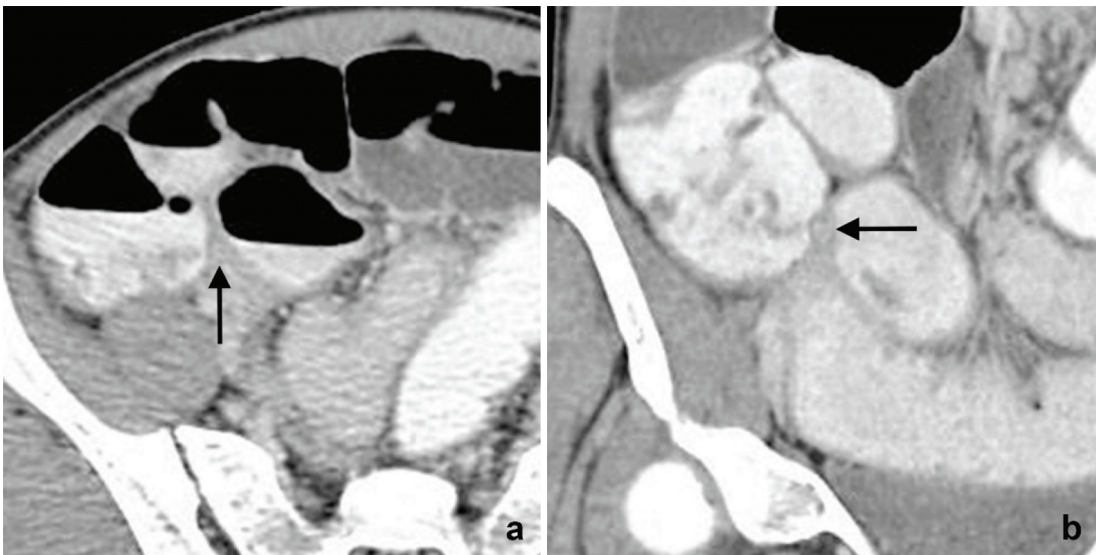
Axial (a) and coronal (b) contrast-enhanced CT images show a normal appendiceal base (arrow). It is very difficult to identify the appendix and periappendiceal inflammation due to the paucity of the intra-abdominal fat. Acute appendicitis was confirmed upon surgery.
